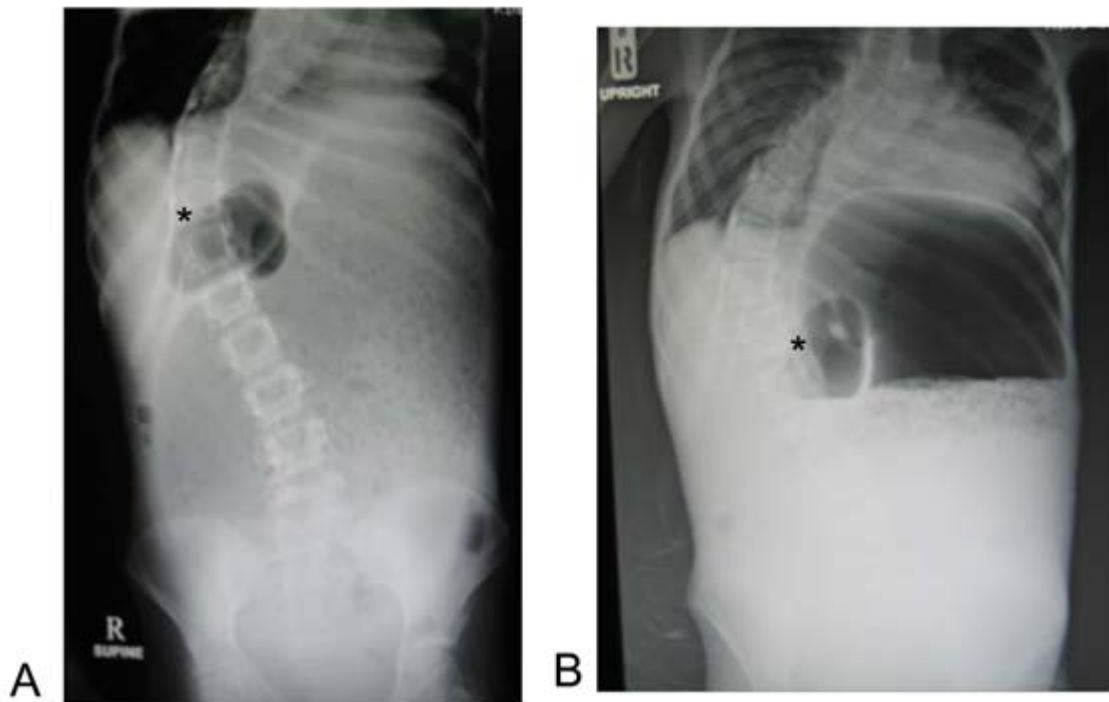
Abdominal x-rays demonstrate markedly distended stomach with retained food particles in the supine film (A) and air fluid level in the upright film (B). Air bubble in the duodenal bulb is also seen (asterisk).
